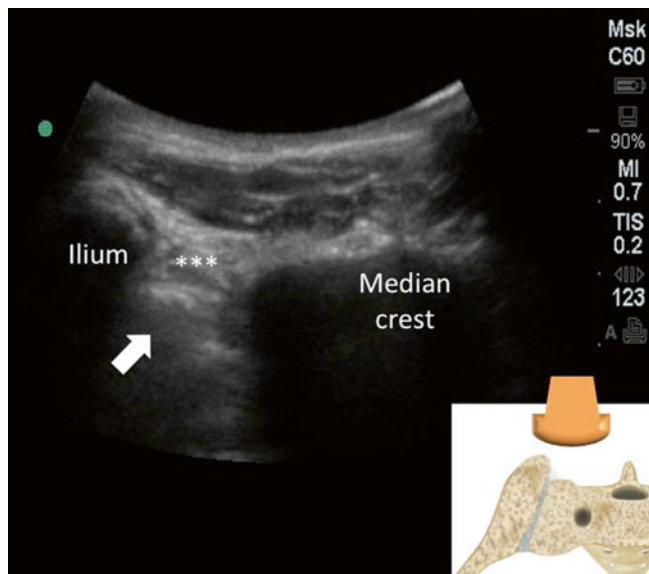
Sonography of the upper sacroiliac joint (SIJ). The probe position was indicated in the insertion in the lower right corner. The SIJ was indicated by the bold arrow. Note the prominence of the ilium. * dorsal sacroiliac ligament (Reproduced with permission of Philip Peng Educational Series)
